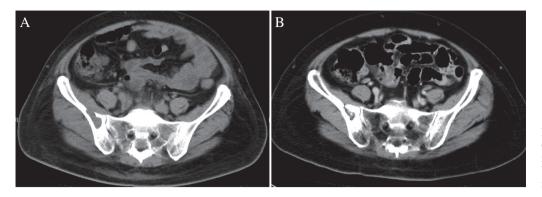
Abdominal CT (A) Osteolytic lesion was detected in right pelvis. (B) Pelvic tumor became smaller and changed into osteosclerotic lesion.
